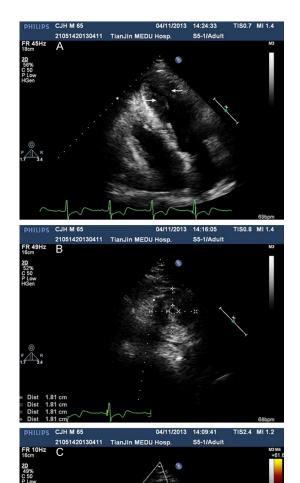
A. Echocardiography showed LV AHCM on unconventional views (arrows). B. Echocardiography showed LV AHCM on short-axis views. C. Color doppler flow imaging revealed paradoxical jet flow to the left ventricle during early diastole (arrow).
